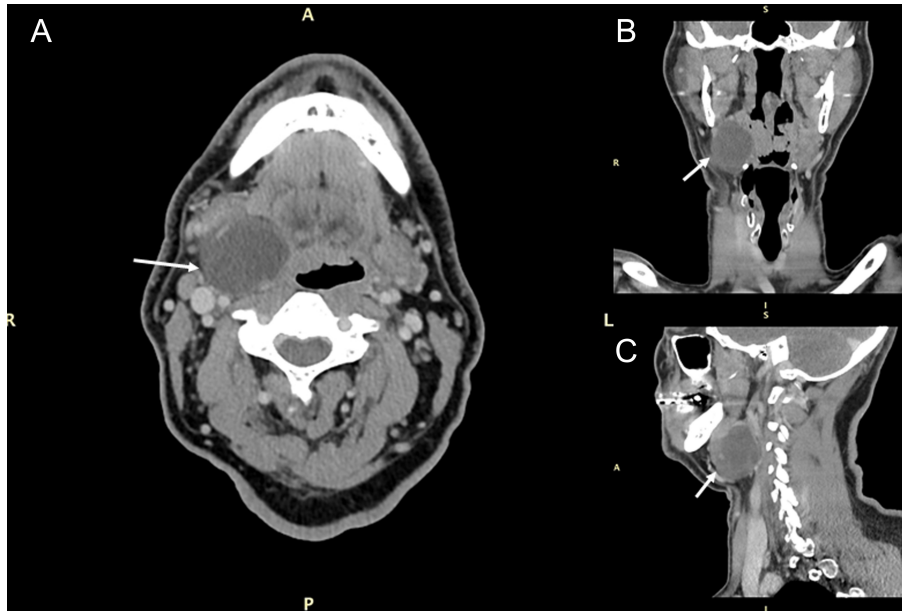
Head and neck contrast-enhanced computed tomography showing in axial (A), coronal (B), and sagittal (C) views a mass (indicated by the arrow) approximately 3.5 cm in its main diameter, not contrast-enhancing.
